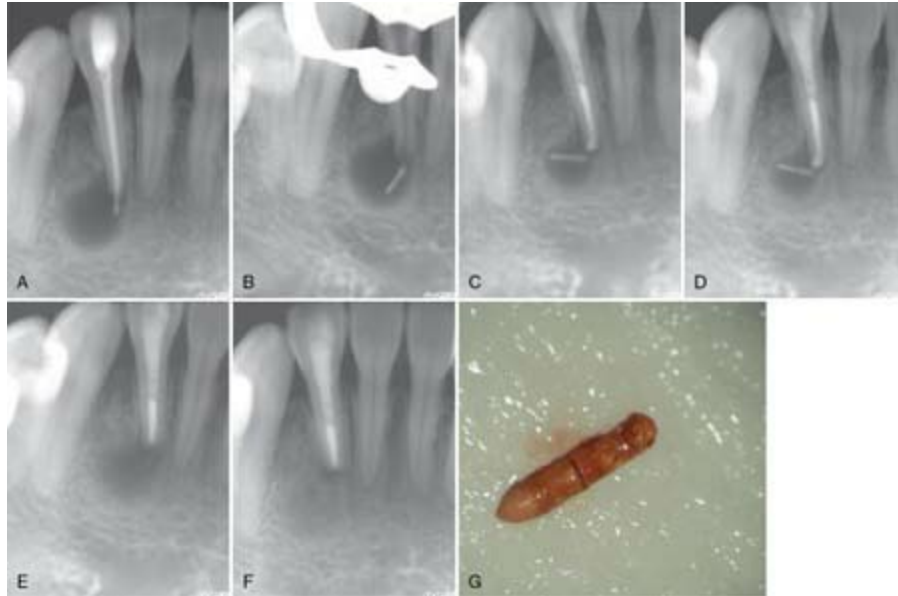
Root filling materials extruded beyond the radicular foramen. A, Preoperative radiograph showing overextension of the root filling material with a large lesion associated with the root. B, Root filling in the canal was mechanically removed, but the extruded portion of it remained in the periradicular tissues. C, Mineral trioxide aggregate (MTA) was filled in the canal with the extruded portion remaining in the lesion. D, Six-month postoperative radiograph showing the reduced size of the lesion, but the lesion surrounding the extruded portion stayed the same in size for the next 6 months, indicating infection of the extruded gutta-percha point. The extruded portion was surgically removed from the lesion at this point. E, Three-month follow-up radiograph after the surgery showing the resolving lesion. F, Twelve-month follow-up radiograph after the surgery showing a more periradicular healing. G, Gutta-percha point retrieved from the lesion.
